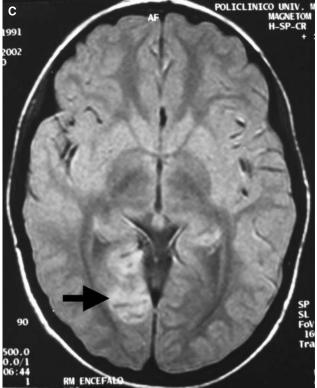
(A) Axial CT scan of the brain showing occipital lobe calcifications (white arrow); (B) axial T2-weighted brain MR images showing diffuse left periventricular high signal lesions suggestive of cortical dysplasia; (C) other aspects of abnormal brain signal lesions in NF2 suggestive of cortical dysplasia (posterior periventricular high signal lesion along the sulci and convolutions: black arrow) [reprinted with permission from Ruggieri et al. 2005].
